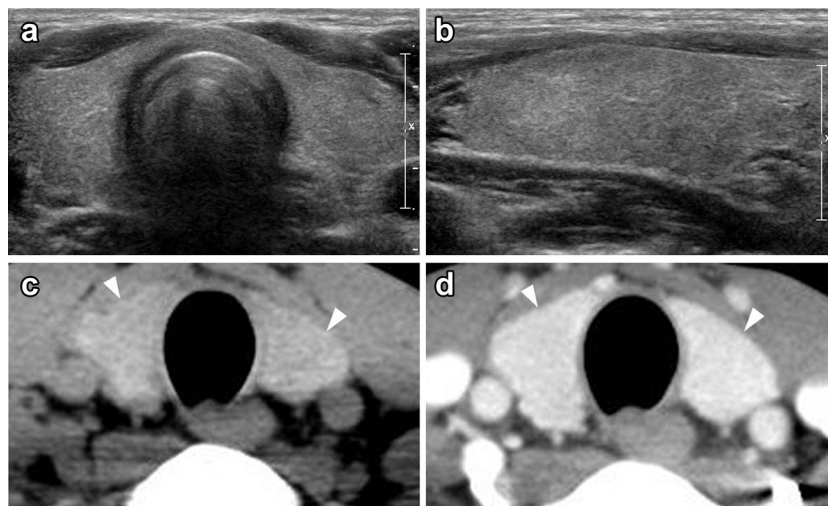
A 35-y-old man with a normal thyroid diagnosed as “normal” by both ultrasound and computed tomography. Transverse (a) and longitudinal (b) gray-scale sonograms of the thyroid gland reveal iso-echogenicity, fine echotexture, a smooth margin, normal anteroposterior diameter and normal vascularity. The non-enhanced (c) and contrast-enhanced (d) computed tomography images of the thyroid gland (*arrowheads*) reveal iso-attenuation, homogeneous attenuation, normal anteroposterior diameter, a smooth margin and homogeneous parenchymal enhancement.
